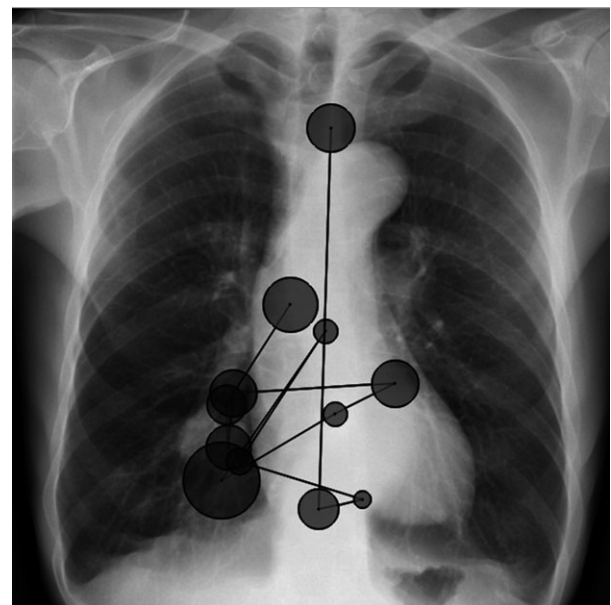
Eye movements of one student studying a chest radiograph. Circles are fixations; the size of the circle represents its duration. The lines between the circles are saccades
